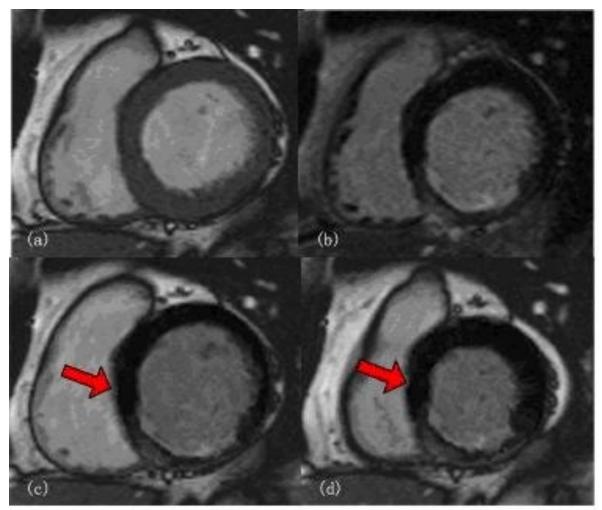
(a). An MR image shows myocardium at the end diastole. (b). A CE MR image shows MI as a lighter shade on the image. (c). The CE MR image was warped to the end diastole using our method. (d). The CE MR image was warped to the end systole. Cardiac motion can be revealed preliminarily by the comparison of the end diastolic image and the end systolic image. The arrow indicates the heart muscle which moves abnormally but is not contrast-enhanced, suggesting the potential hibernating myocardium.
